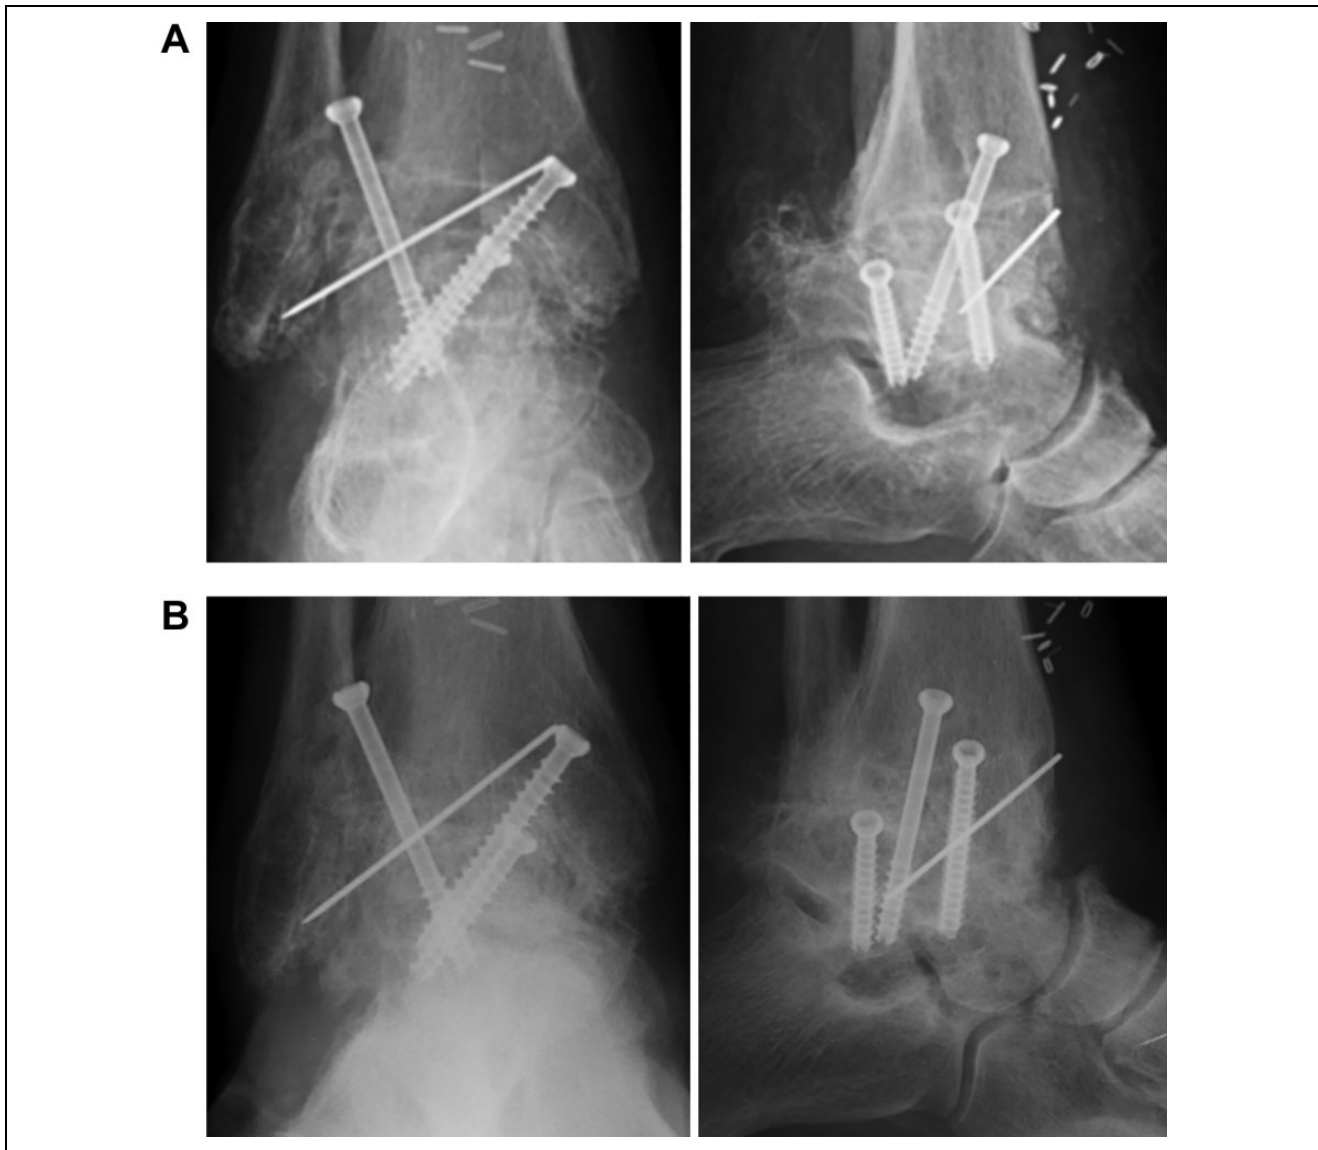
(A) Anteroposterior and lateral radiographs of the patient obtained 4 weeks status post tibiotalar arthrodesis with 3 screws transfixing the tibiotalar joint. The MFC bone flap is well opposed to the tibia and talus and secured in the defect seen in Figure 2 with Kirschner wire fixation. (B) Anteroposterior and lateral weightbearing radiographs obtained 1 year postoperatively demonstrating successful ankle fusion with full incorporation of the vascularized bone graft. MFC, medial femoral condyle.
